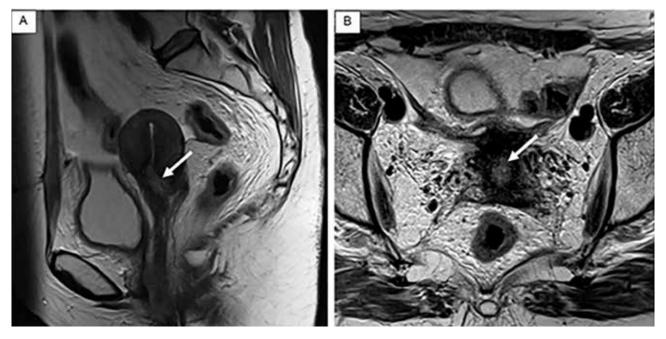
Pelvic MRI, T2W/TSE sequence, lateral (A) and axial (B) planes. Cervix uteri are large; its structure is heterogeneous – changes after chemoradiotherapy. Infiltration with abnormal SI is observed along the cervical canal – residual tumor masses
